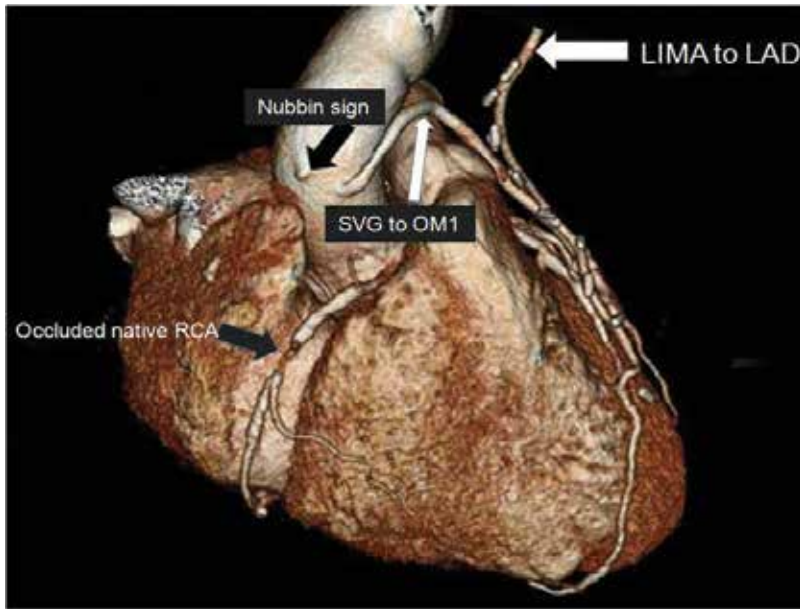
A 65-year-old male patient who underwent left internal mammary artery to left anterior descending artery graft (LIMA to LAD) as well as two venous grafts, saphenous vein graft to right coronary artery (SVG to RCA), and SVG to first obtuse marginal branch (SVG to OM1) 7 years ago. CTA was performed because of recurrence of atypical angina. Volume-rendering images showed that the LIMA to LAD and SVG to OM1 grafts are patent. The image showed the nubbin sign along the right anterolateral ascending aorta, indicating an occluded SVG to RCA. Additionally, occlusion of the native RCA is seen as well.
